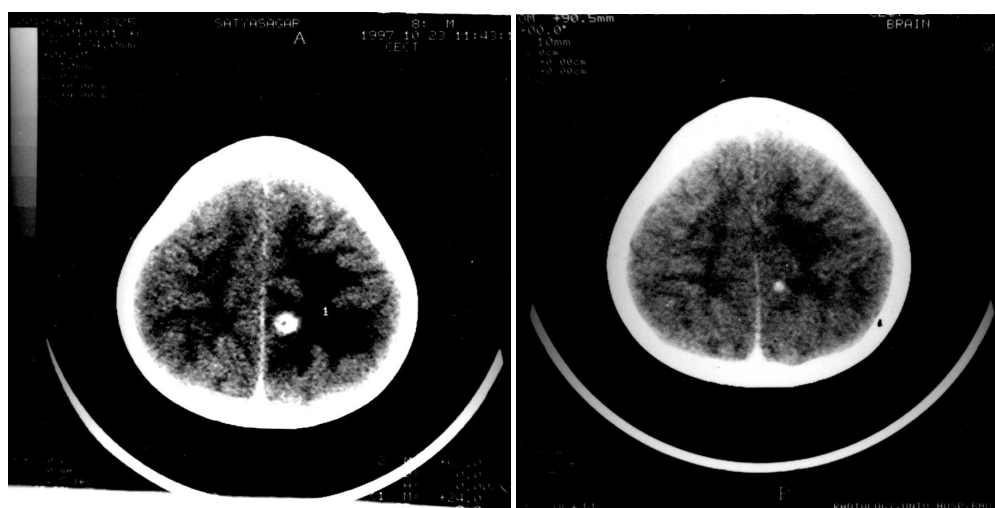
(a) Ring enhancing CT lesion; (b) plain CT scan after 2 months showing calcification of the same lesion.
